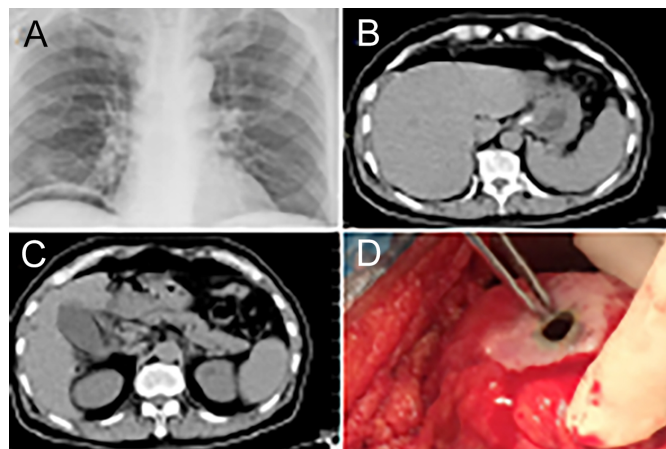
Preoperative examinations and intraoperative images. Chest radiograph showed free gas in the abdominal cavity (A); Abdominal CT scan showed free gas and peritoneal effusion (B, C); Antrum anterior wall tumor was found with perforation (D).
